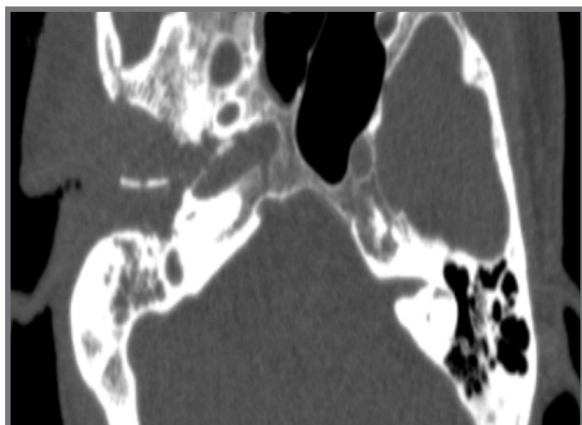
HRCT temporal bone showing erosion of the anterior canal wall extending into the TMJ, mastoid air cells
